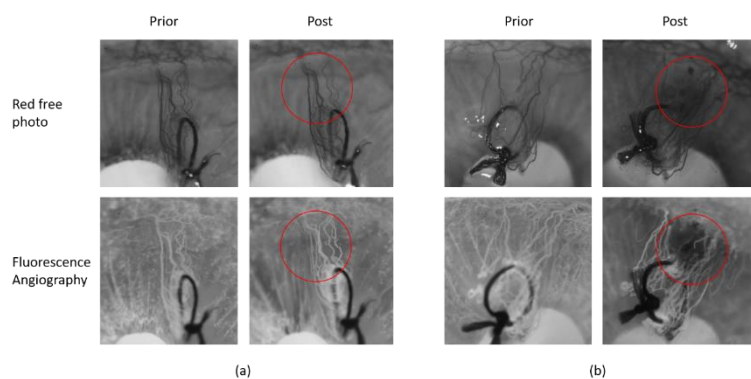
Phase control in vivo: (a) Out of phase, (b) In phase. The applied ultrasound pressure was 0.425 MPa at 0.5 MHz. The applied laser fluence was 3.14 mJ/cm<sup>2</sup>. The laser spot size is 5 mm diameter and the duration time is 10 min.
